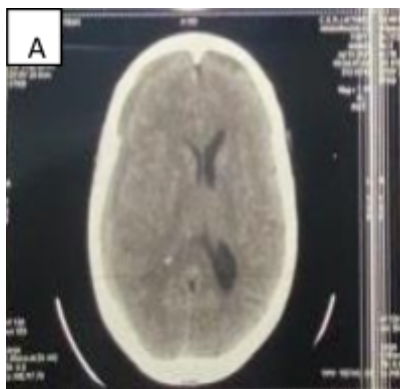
Cerebral CT scan without contrast injection showing a right hemispheric chronic subdural hematoma
